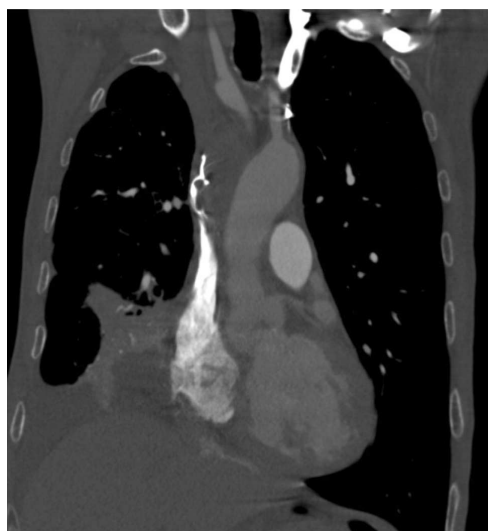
Computed tomography (CT) reveals SVC obstruction.
